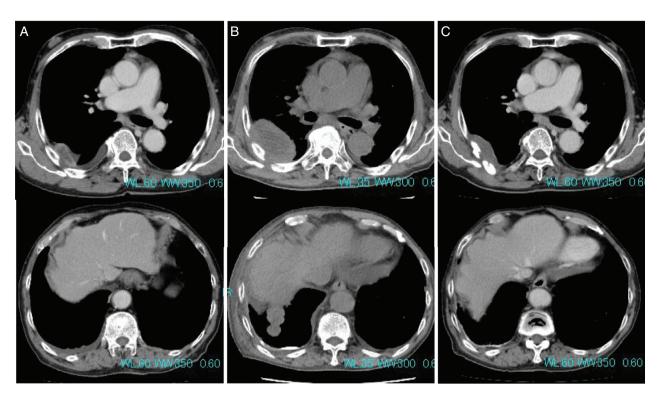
(A) Primary tumour on chest computed tomography (CT). (B) Chest CT after systemic chemotherapy showing an increase in primary tumour and new metastasizes. (C) Chest CT after immune checkpoint inhibitor revealing the remarkable tumour response.
